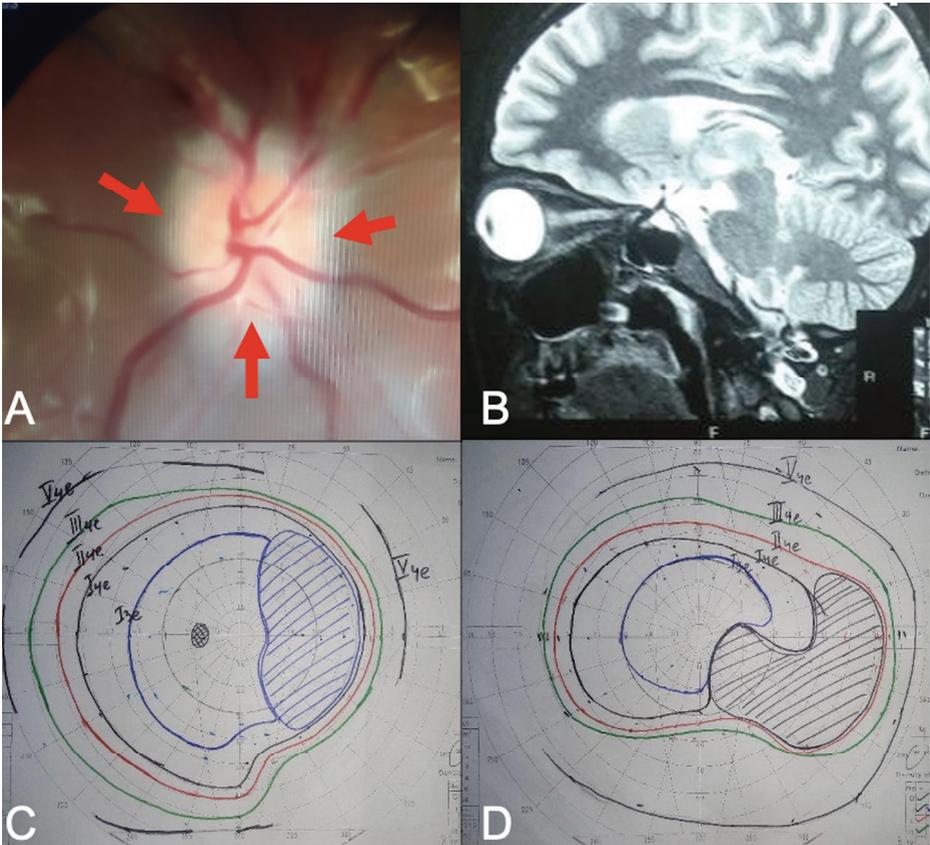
(A) Hyperaemic right optic disc with undefined margin. (B) Signs of optic neuritis in the right eye with optic nerve enhancement in T2-weighted magnetic resonance image. (C) Goldman kinetic perimetry of the left eye at the 1-week follow-up showing relative paracentral scotoma. (D) Absolute cecocentral scotoma in the right eye.
